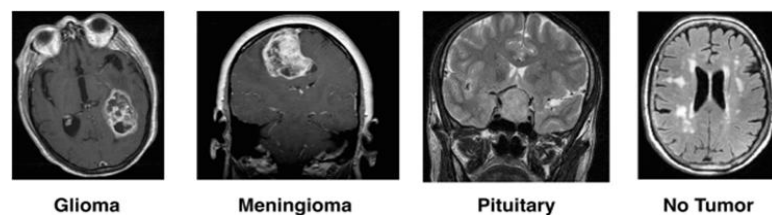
Four (4) types of MRI images of brain tumor
